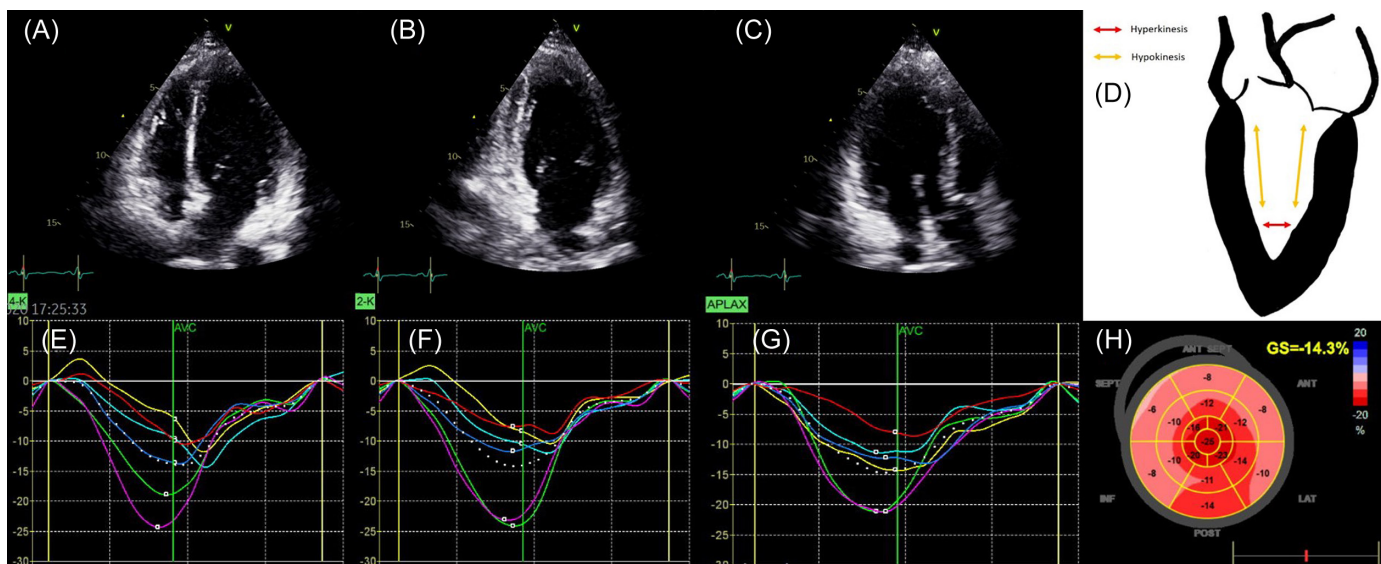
The top transthoracic bidimensional echocardiography shows apical 4- (Panel A), 2- (Panel B), and 3-chamber (Panel C) views of the left ventricle (LV). In this case, apical hyperkinesia associated with hypokinesia of the basal and mid-LV segments (see Panel D at the right) was reported. Below, 2-dimensional speckle-tracking echocardiography analyses for the apical 4- (Panel E), 2- (Panel F), and 3-chamber (Panel G) views. In Panel H, the longitudinal strain bull's eye plot shows a significant reduction of global longitudinal strain (GS) (-14.3%) with impairment mainly in the basal and mid-LV segments.
